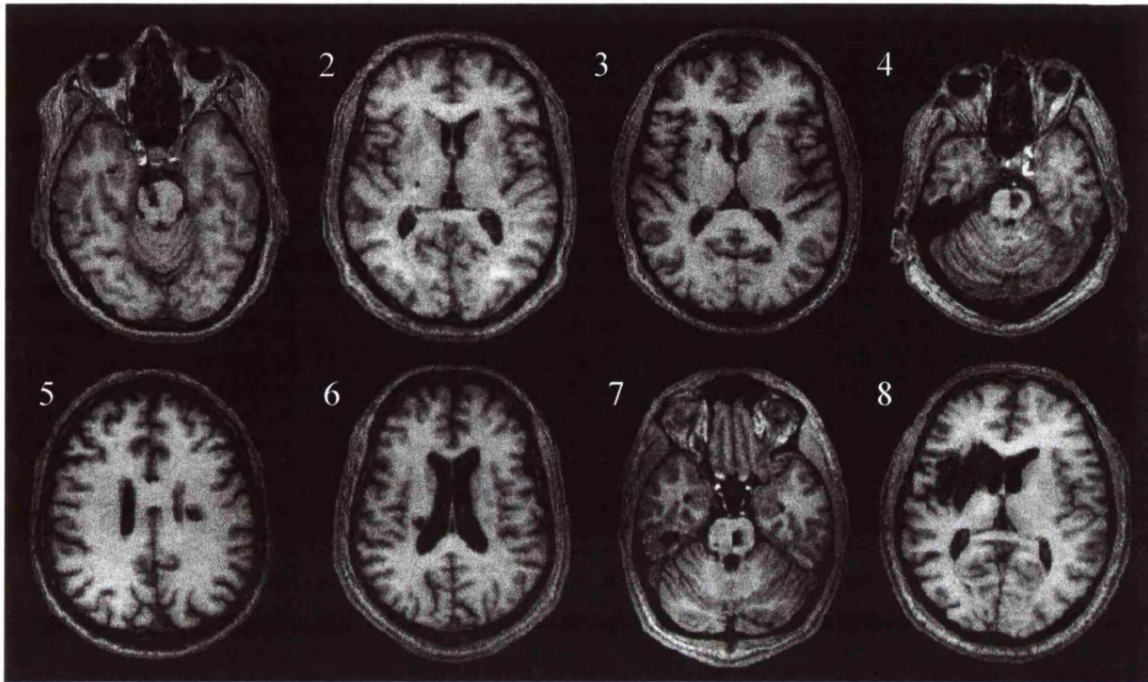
Axial structural T_1 -weighted MRI scans at the level of maximum infarct volume for each patient. The front of the brain is displayed at the top, and the right side on the left.
